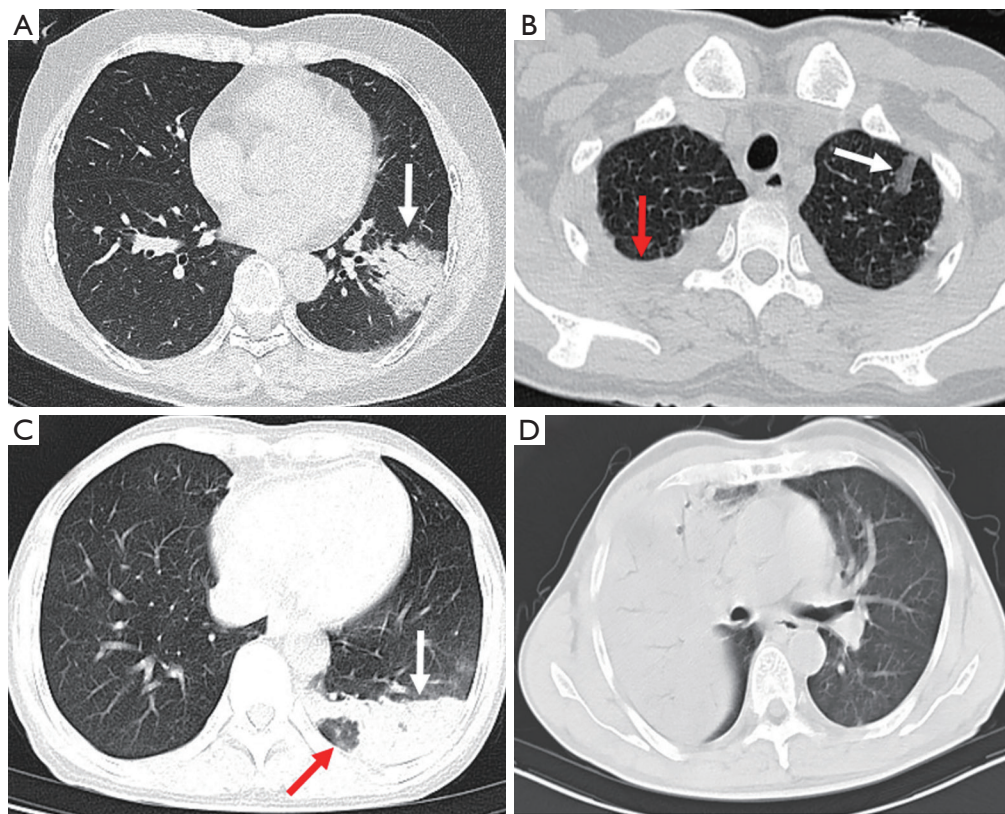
CT distribution patterns of CPP. (A) The lesion was the distribution of bronchial vascular bundle which was parallel to the bronchial vascular bundle as shown by the white arrow. Air bronchogram was observed inside, the center of the lesion was with consolidation shadows and ground-glass shadows were observed around the center. (B) The lesion was the ground-glass shadows of the secondary pulmonary lobules, as shown by the white arrow. In addition, bilateral pleural effusions could be observed, as shown by the red arrow. (C) The lesion was distributed under the pleura as shown by the white arrow. In addition, the red arrow showed the pulmonary lobule infarct sign, indicating that the lesion was formed by the fusion of the secondary pulmonary lobules, while the local secondary pulmonary lobules were not affected and were with a relatively low density. (D) The lesion was diffusion to all pulmonary lobes with air bronchogram observed inside. In addition, the bronchus was compressed and narrowed but still unobstructed. CT, computed tomography; CPP, *Chlamydia psittaci* pneumonia.
